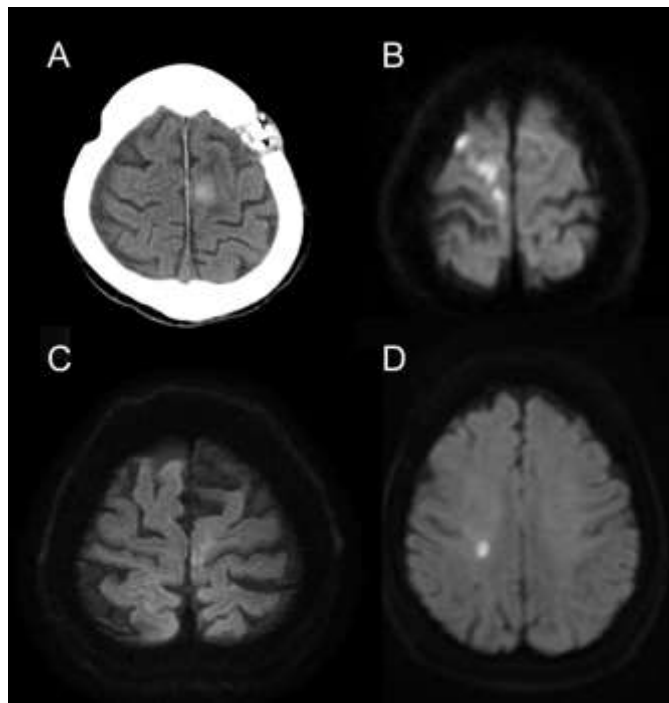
Neuroimaging studies of patients with pure motor monoparesis (PMM) of lower extremities. (A) Computed tomography of a patient with PMM of the right leg due to traumatic intracerebral hemorrhage located in the left leg motor area. (B) Diffusion-weighted images (DWI) of a patient with PMM of the left leg due to acute cerebral infarction located in the right anterior cerebral artery (ACA) territory. (C) DWI of a patient with PMM of the right leg showing acute infarction located in the left ACA territory. This case presented with monoparesis restricted to the foot. (D) DWI of a patient with left leg PMM due to acute cerebral infarction located in the right central semiovale (D).
